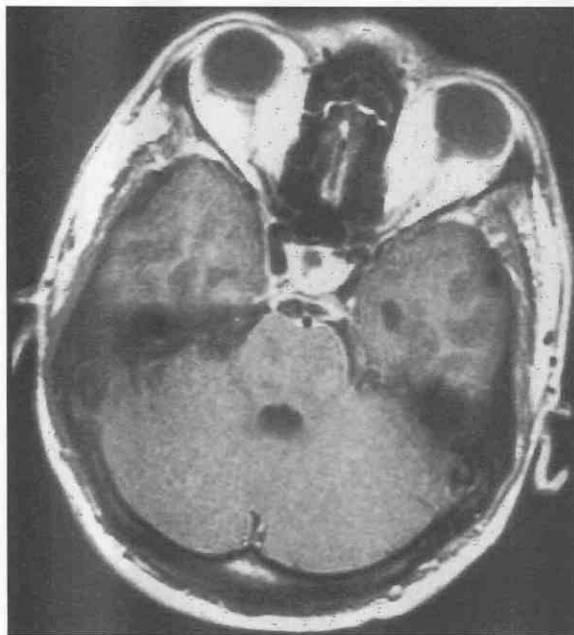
Cisternal cyst with basal meningeal enhancement. Gadolinium-enhanced MRI study shows ovoid ringlike enhancement in the pontine cistern and enhancement at the left ambient cistern.
